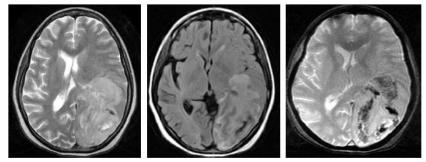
T2 & FLAIR hyperintensity with GRE blooming in left parieto-occipital region – s/o of haemorrhage
